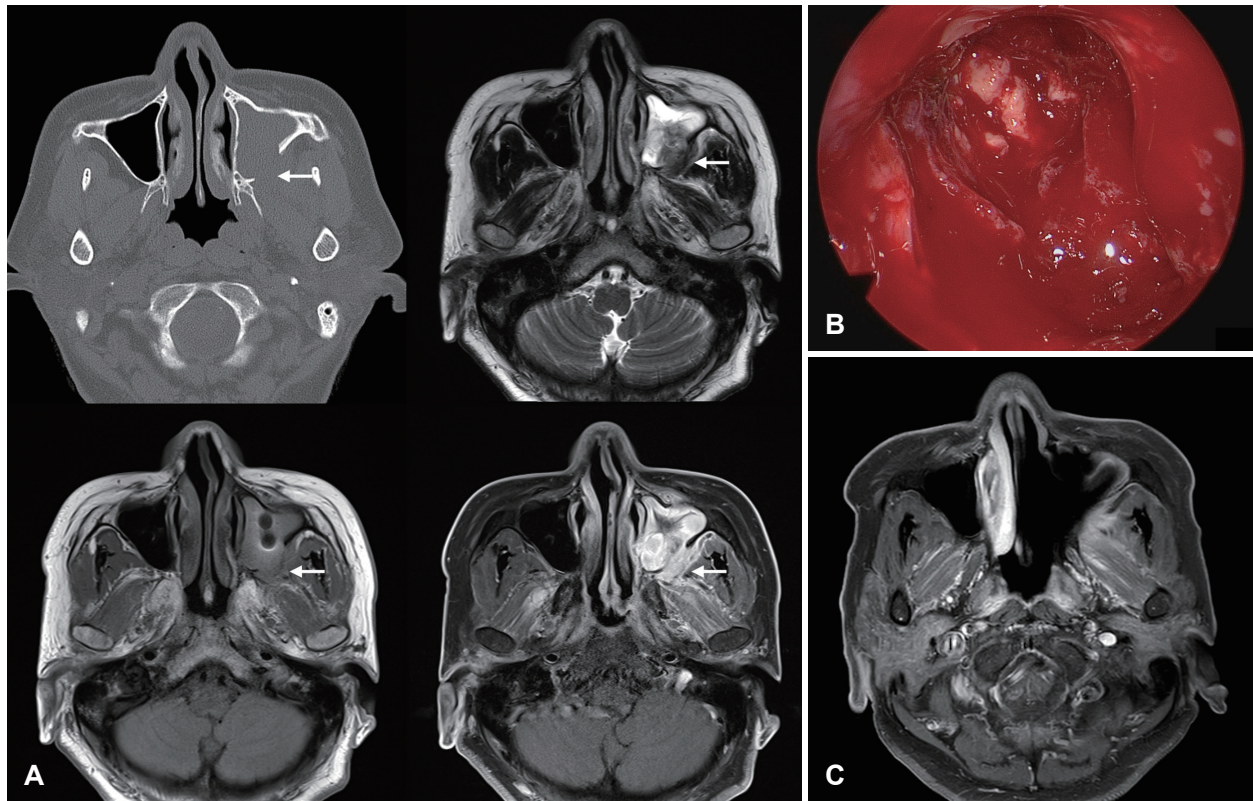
MR images and intraoperative finding of a patient with chronic invasive fungal sinusitis. A: The CT scan revealed a focal bone defect with focal sclerosis and periosteal reaction in the posterior wall of the left maxillary sinus (arrow), as well as potential diffuse soft tissue infiltration along the left inferior orbital fissure and pterygopalatine fossa. These findings suggested a tumorous condition in the left maxillary sinus. MR images, infiltrative, reveal a poorly enhancing, T2 intermediate infiltrative soft tissue lesion on the left posteroinferior wall of the maxillary sinus (arrow), with focal bone destruction and retroantral fat infiltration. B: Necrotic tissue in the left pterygopalatine fossa and infratemporal fossa, including the lateral pterygoid and temporalis muscles, was completely resected via endoscopic endonasal approach. Chronic invasive fungal sinusitis by *Aspergillus* was diagnosed. C: Postoperative gadolinium-enhanced MR image showed no remnant LoCE lesions, and the patient was successfully treated with surgical debridement and antifungal therapy.
